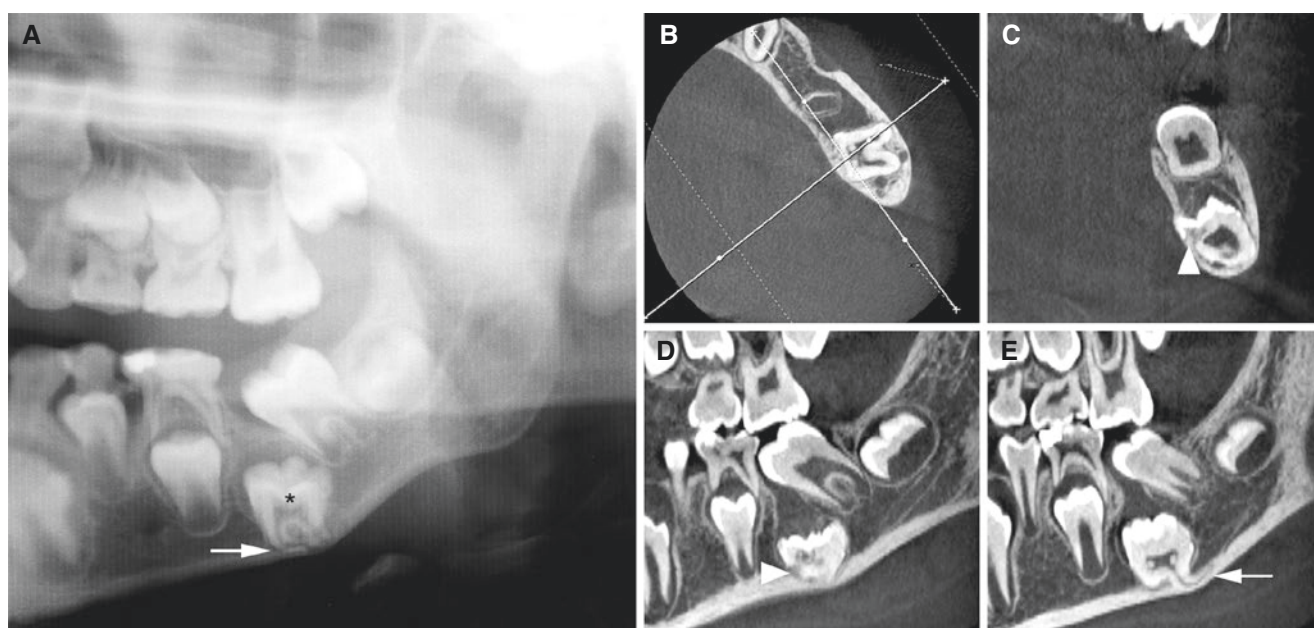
First molar not erupted, mandible; 8-year-old male. (A) Panoramic view shows the impacted molar (*asterisk*) located in the cortex of the inferior mandibular border with about 90° angulation of mesial root (*arrow*). (B) Axial (with cursor lines), (C) oblique coronal, and (D, E) oblique sagittal CBCT images show the impacted molar
